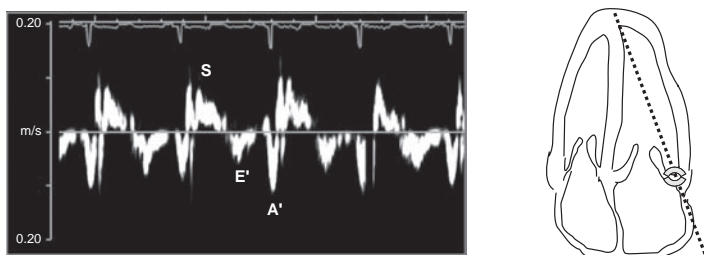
Tissue Doppler imaging (TDI) for diastolic function recorded from the apical four-chamber window using a 2-mm sample volume positioned in the lateral wall 1 cm from the mitral annulus. The TDI signal is toward the transducer in systole (S) as the myocardium moves toward the apex. In diastole, the myocardial velocity is directed away from the transducer first with early diastolic filling (E') and then with atrial contraction (A').
